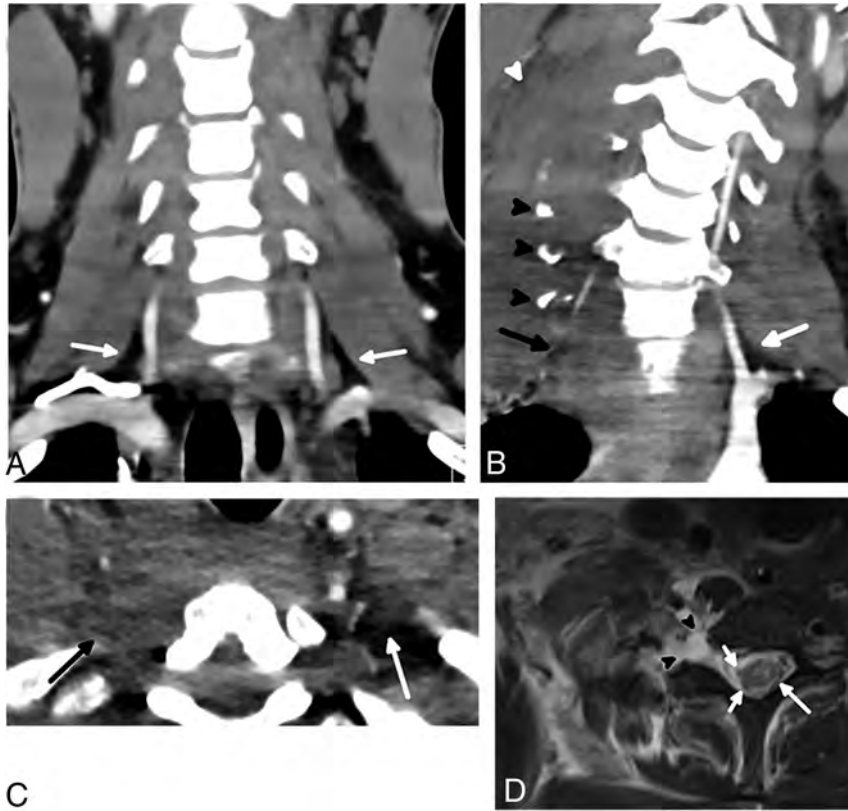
Normal and abnormal interscalene fat pads in different patients. A coronal CT scan in a 26-year-old man (A) without BPI demonstrates smoothly margined scalene muscles with normal interscalene fat pad (arrows). The coronal plane is a good place to assess the interscalene fat pad quickly by looking for this triangle of fat in the region of the proximal vertebral arteries, which should not have any stranding or hematoma. A coronal CT scan in a 25-year-old man (B) with BPI shows complete effacement of the right interscalene fat pad (black arrow) compared with the normal left interscalene fat pad (white arrow). Multiple displaced cervical transverse process fractures (black arrowheads) with scalene enlargement and edema (white arrowhead) are also present. An axial CT in the 25-year-old patient (C) shows the interscalene fat pad effacement (black arrow) in a different plane, compared with the normal left interscalene fat pad (white arrow). An axial T2-weighted MR imaging with fat saturation (D) performed a day later in the injured patient shows avulsion of the ventral and dorsal nerve rootlets (short white arrows), which was better appreciated when reviewing multiple sequential images. The spinal cord is slightly eccentric to the left and has abnormally increased signal (long white arrow), most pronounced within the gray matter. A large pseudomeningocele is present (arrowheads).
